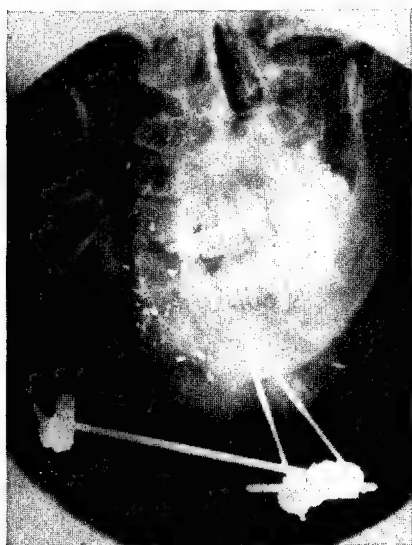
Roentgenogram of patient shown in figure 8.
